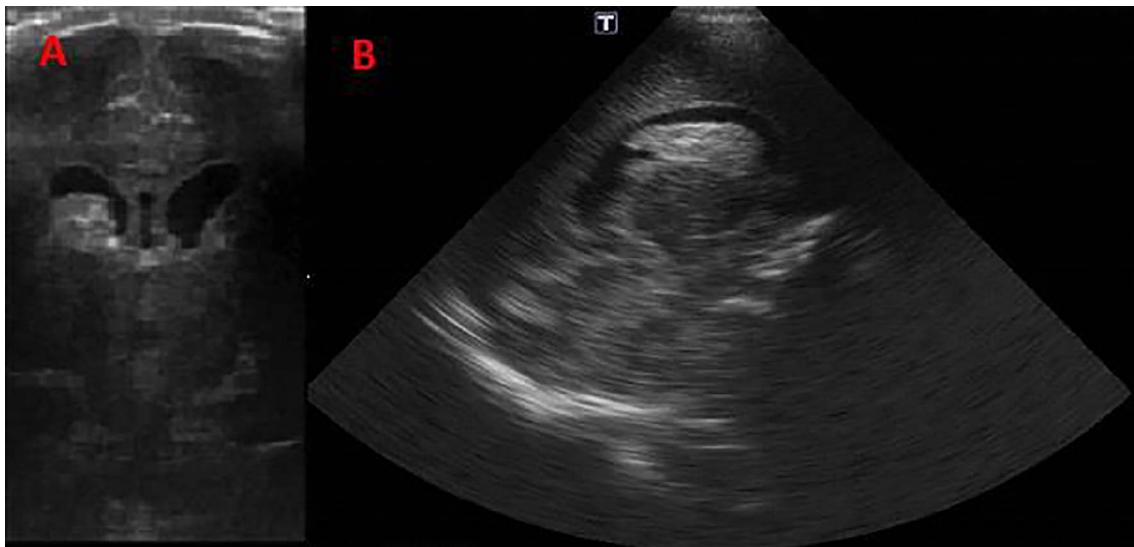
Transfontanelle ultrasound of case 1 performed 4 days after birth showing a Papile grade 2 germinal matrix hemorrhage with ventricular spillage and normal ventricular size. (A) Coronal view. (B) Sagittal view.
